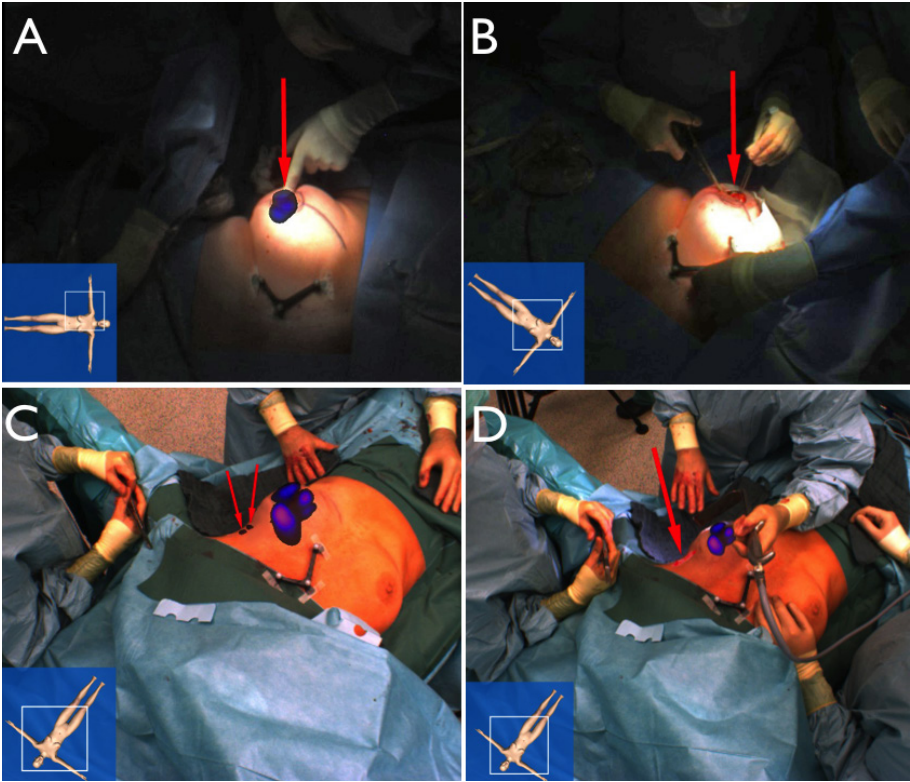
Freehand SPECT based device system used for radioguided surgery in a patient with non-palpable breast cancer. (A) Overlay of freehand SPECT 3-D image on the video display shows high retention of radiocolloid at the intratumoural injection site. (B) After tumour removal, the absence of radioactivity accumulation in the surgical field confirms complete excision of the tumour. (C, D) A similar approach is used to guide the surgeon for complete removal of SLNs (red arrows).
